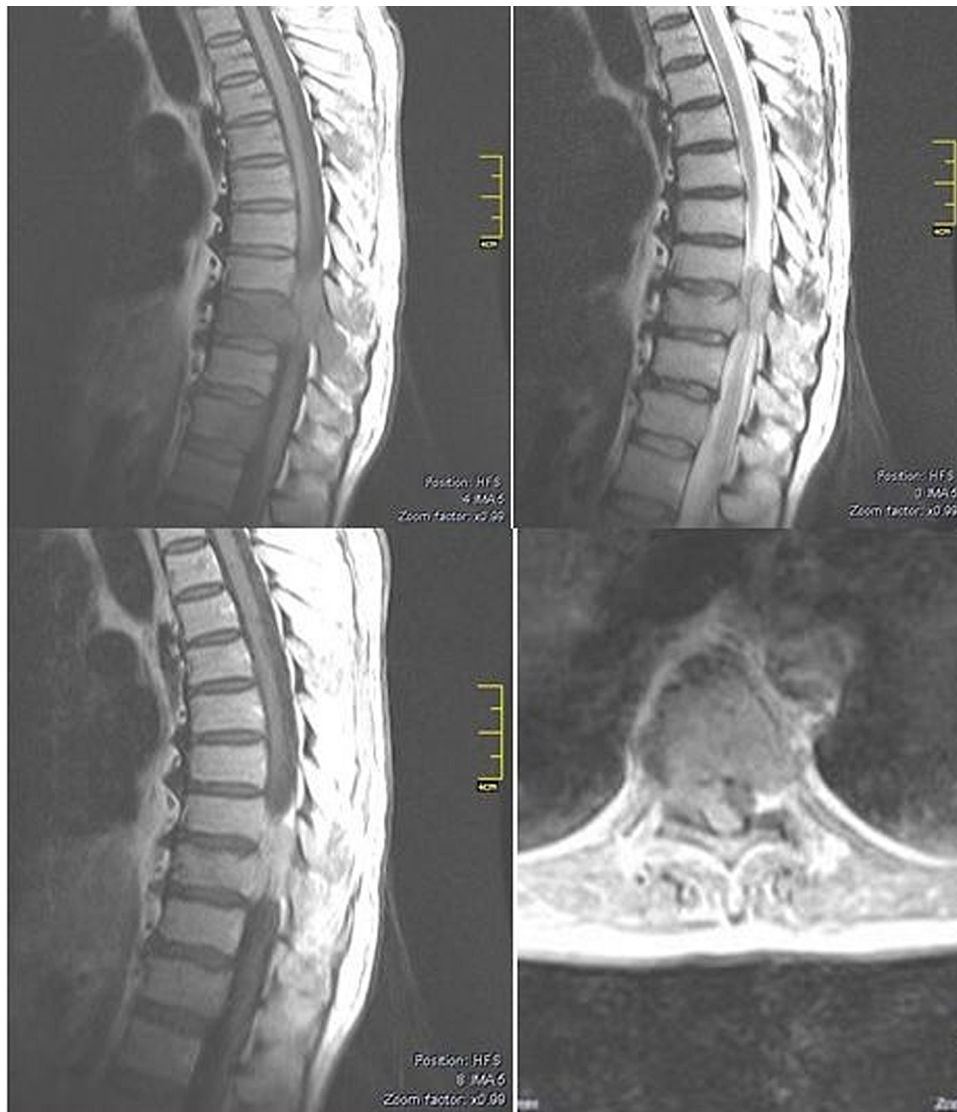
A. T1 thoracic sagittal MRI shows epidural metastatic ENB in T9–10 level. B. T2 thoracic sagittal MRI shows epidural metastatic ENB in T9–10 level. C. T1 thoracic sagittal contrast-enhanced MRI showing intense homogeneous enhancement of epidural metastatic ENB in T9–10 level, and D. T1 thoracic sagittal contrast-enhanced MRI showing intense homogeneous enhancement of epidural metastatic ENB in the left side the T9–10 level of epidural space.
